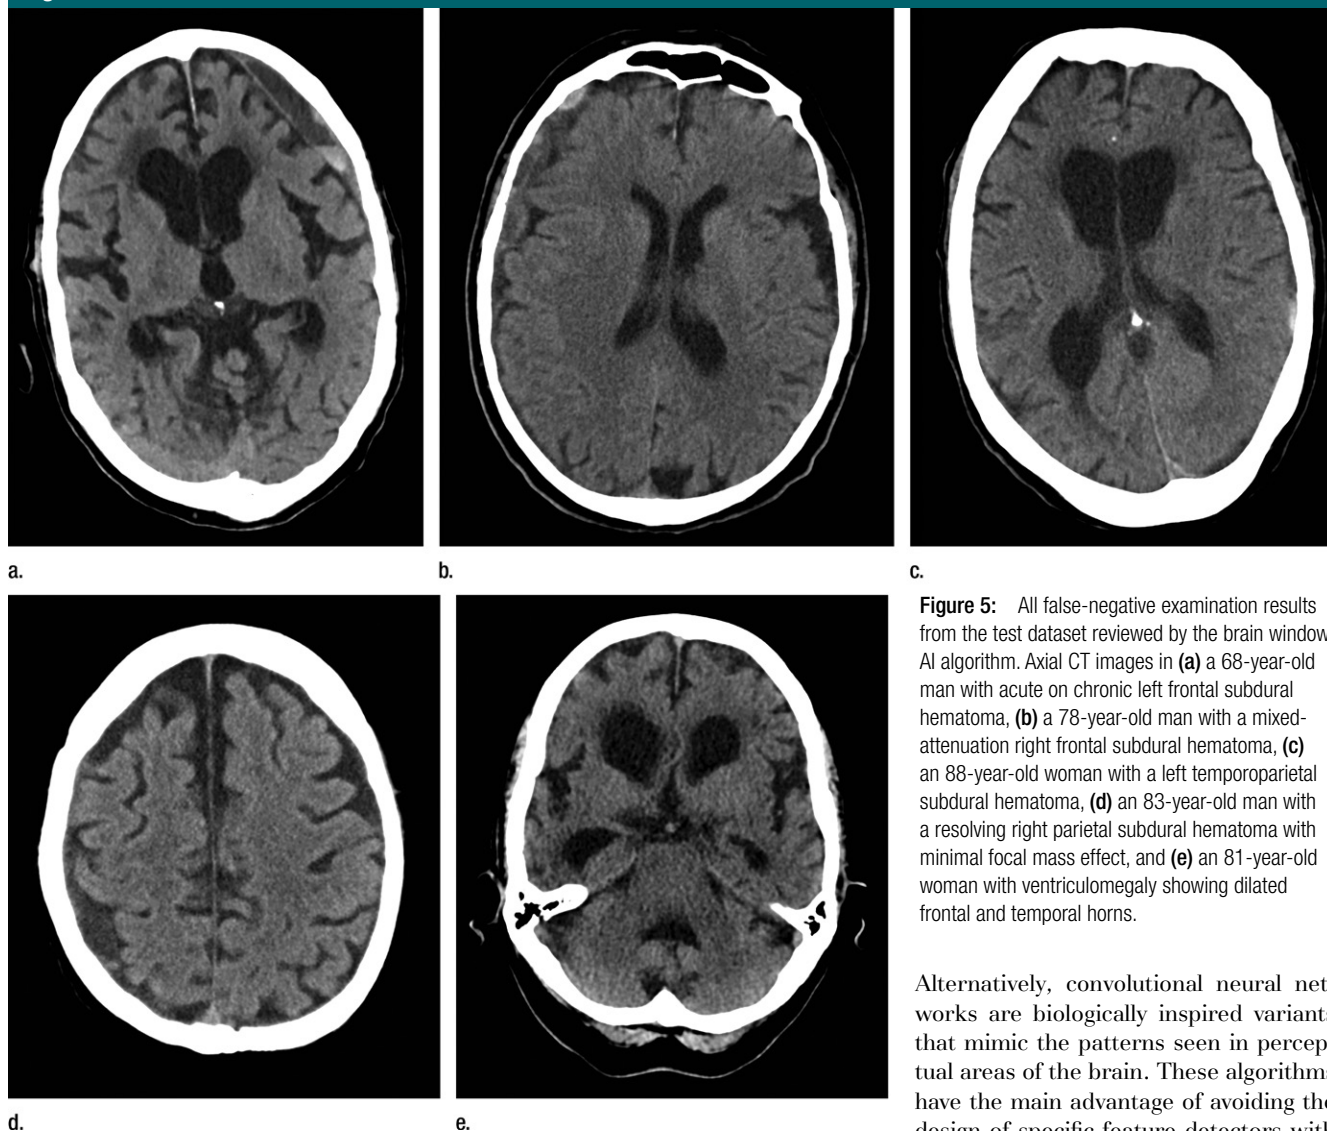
All false-negative examination results from the test dataset reviewed by the brain window AI algorithm. Axial CT images in (a) a 68-year-old man with acute on chronic left frontal subdural hematoma, (b) a 78-year-old man with a mixed-attenuation right frontal subdural hematoma, (c) an 88-year-old woman with a left temporoparietal subdural hematoma, (d) an 83-year-old man with a resolving right parietal subdural hematoma with minimal focal mass effect, and (e) an 81-year-old woman with ventriculomegaly showing dilated frontal and temporal horns.
